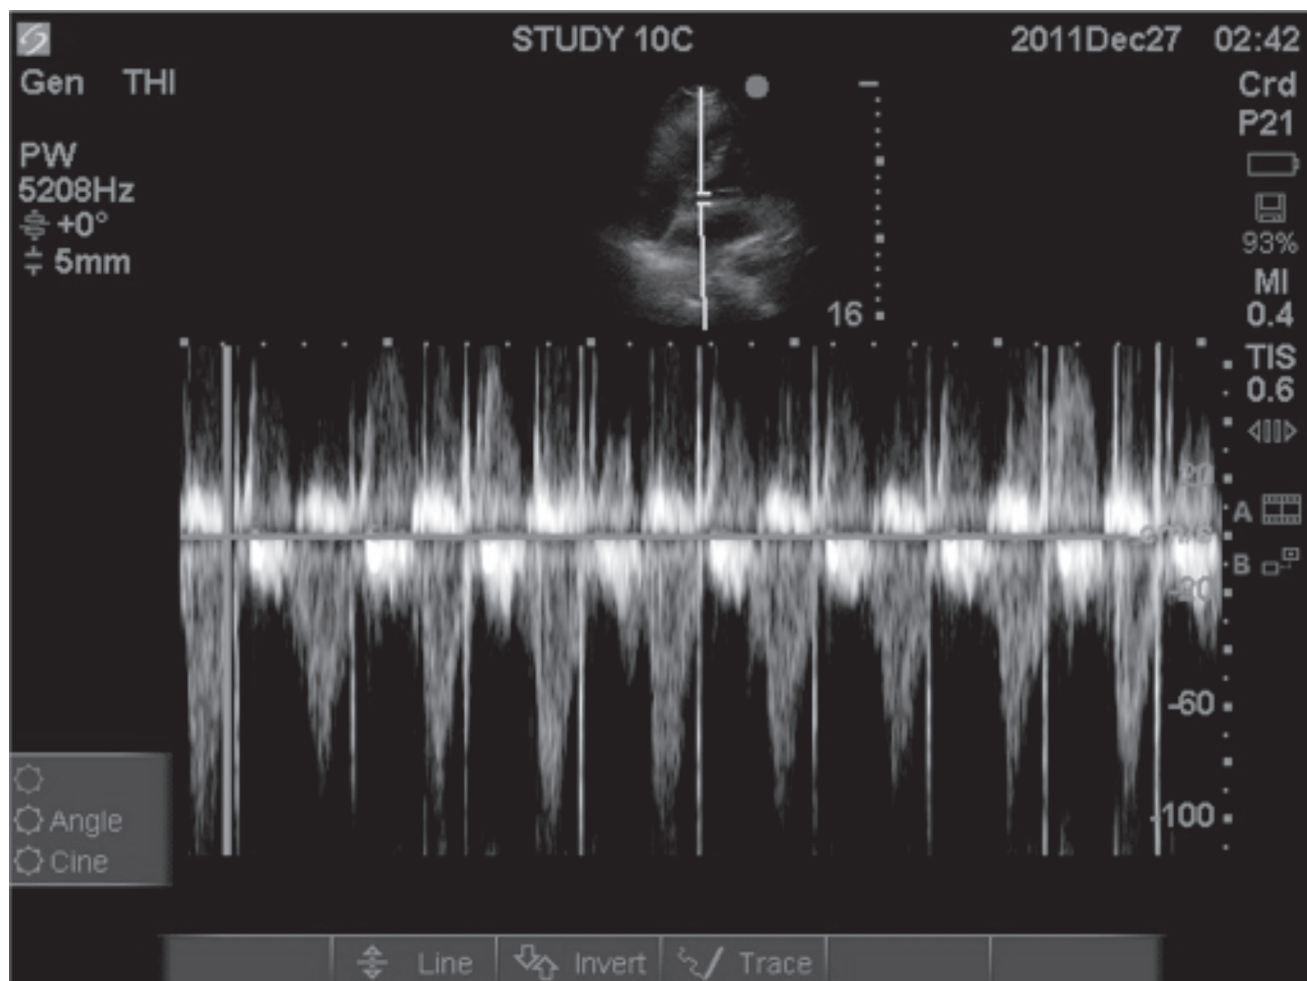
LVOT VTi Pulse Wave Doppler. Cyclical variation in the VTi signal can be seen during the respiratory cycle.
